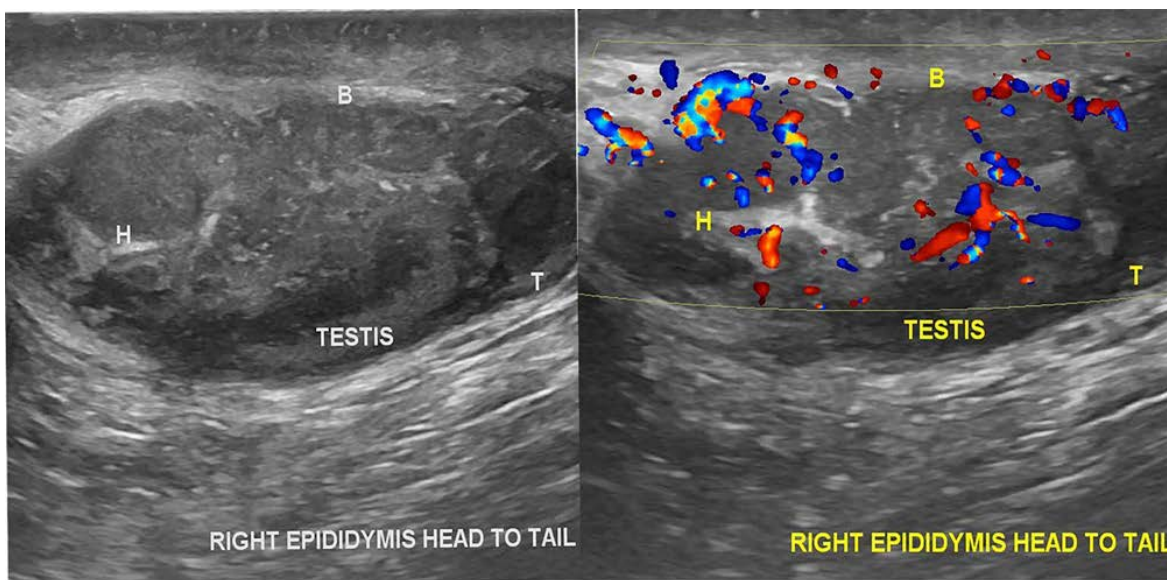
Grey-scale ultrasound and color Doppler images of the patient’s right scrotum at the initial presentation. The right epididymis is involved by the mass and appears bulky, with an abnormal heterogenous hypoechoic appearance. (B – body of epididymis, H – head of epididymis and T- tail of epididymis). Colour Doppler image demonstrates increased vascularity of the right epididymis.
